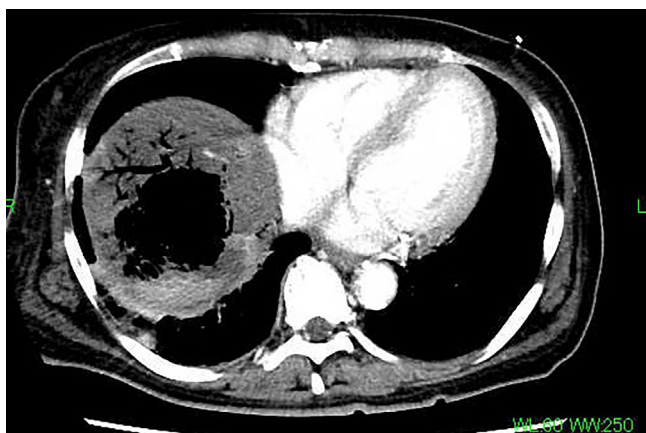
Enhanced CT scan showing gas accumulation in the anterior segment of the liver. Portal gas is also detected.
